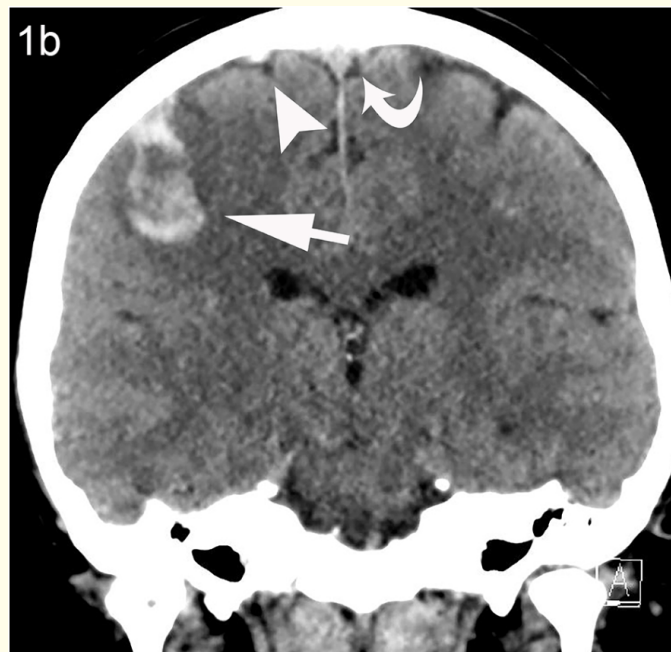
Non-enhanced CT Head [a-b]. Axial (a) and coronal (b) non contrast CT of the brain show right superior frontoparietal parenchymal hemorrhagic hyperdensity (arrow in a, b) with peripheral edematous hypodensity, 'dense vein sign' of thrombosed right vein of Trolard (arrowhead in b) and dense thrombosed superior sagittal sinus (curved arrow in b).
